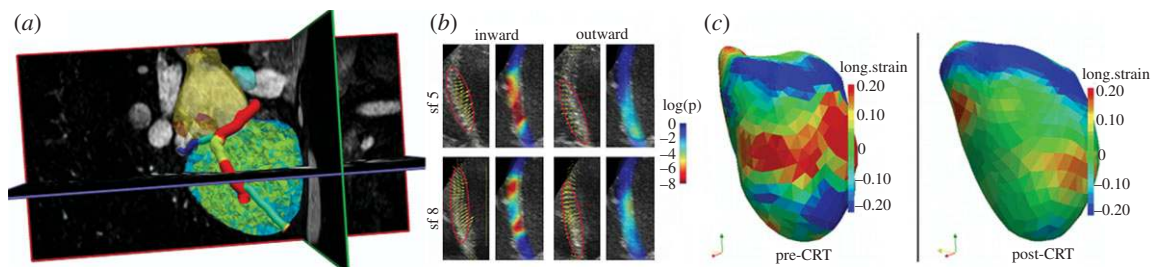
Image analysis for CRT. (a) Segmentation of four chambers, scar (yellow triangles in the myocardium) and coronary venous tree from a three-dimensional whole-heart MRI. (b) Dyssynchrony analysis from two-dimensional echo data showing significant statistical differences (red map) in the inward and outward septal motion during the isovolumetric contraction period between an atlas of normal subjects and these two (top and bottom) septal flash cases. (c) Dyssynchrony analysis from three-dimensional echo data showing the effect of CRT on the longitudinal strain (reduction of large strains, red colour, in the septal wall).
